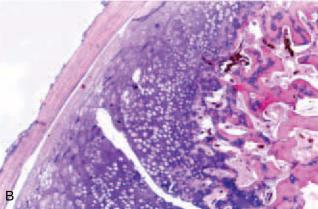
Osteochondroma. A, Radiograph of the distal femur shows a pedunculated mass. The cortex and medulla at the base of the stock are continuous with those of the femur. B, Low-power view shows a cartilaginous cap overlying bony trabeculae.
